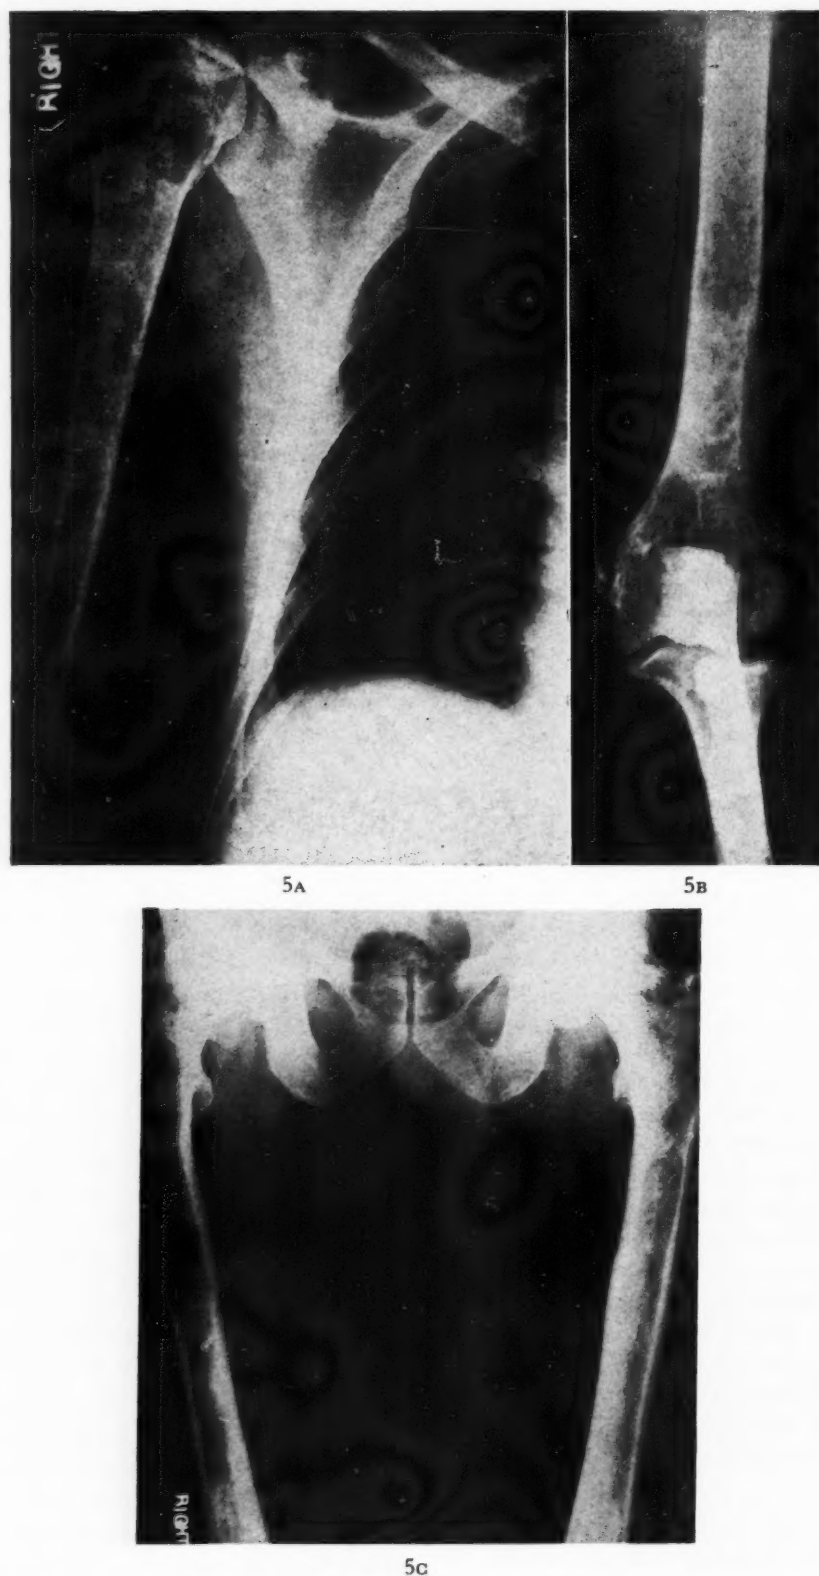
Roentgenograms of patient M. A. A and B, right humerus; changes in the appendicular skeleton showing in addition to the endosteal scalloping an irregular widening of the medullary cavity. C, femurs; rather marked thinning of cortical bone in the right, and some evidence of sclerosis and irregular thickening in the left femur.
